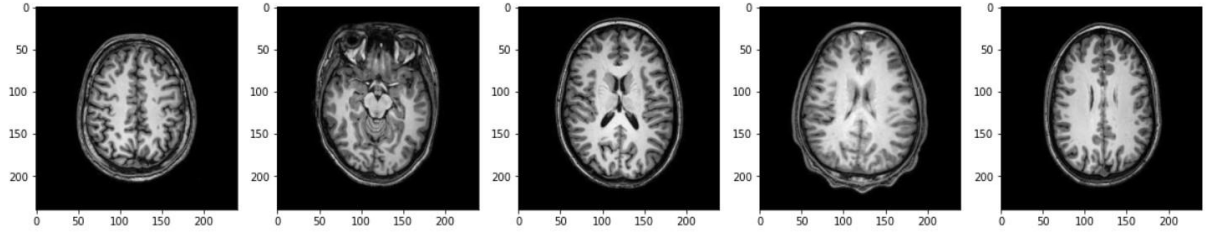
Input MRI images
